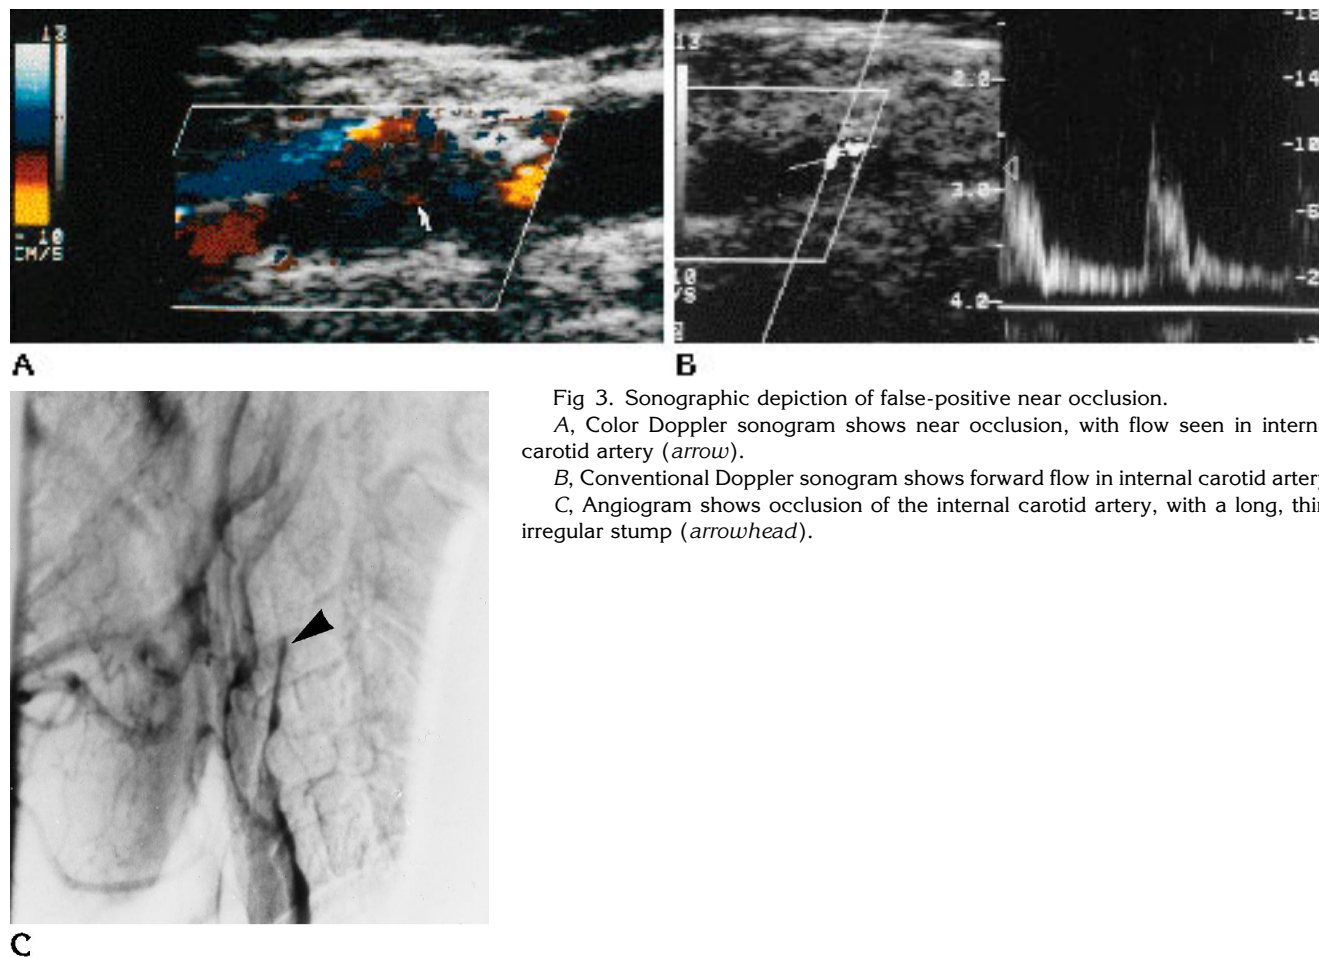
Sonographic depiction of false-positive near occlusion.
